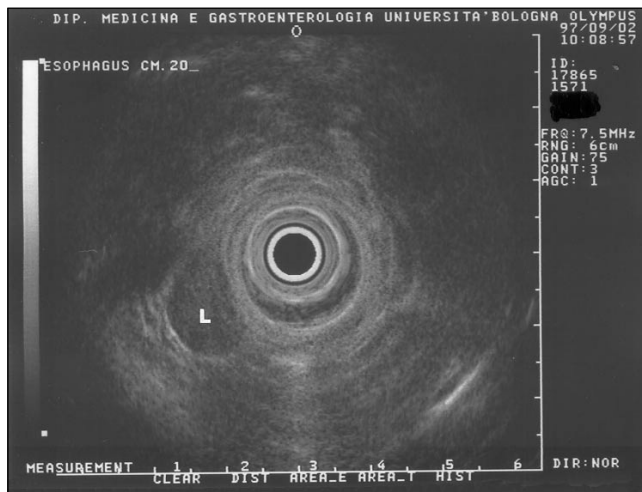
Endoscopic ultrasonography (EUS) radial scanning at 7.5 MHz of a large lymph node displayed outside the esophageal wall in a patient with esophageal cancer. Olympus GF-UM 20, 7.5/12 MHz
